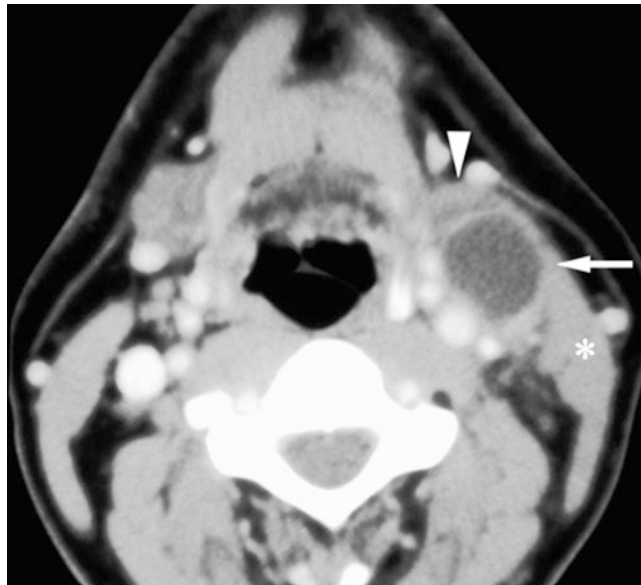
Second branchial cleft cyst; 38-year-old male with soft submandibular tumor at the anterior border of the sternocleidomastoid muscle; cyst confirmed by surgery. Axial post-contrast CT image shows well-defined low-density mass with enhancing peripheral rim in submandibular space (*arrow*), just dorsal to submandibular gland (*arrowhead*), lateral to carotid sheath, and ventral to sternocleidomastoid muscle (*asterisk*)
